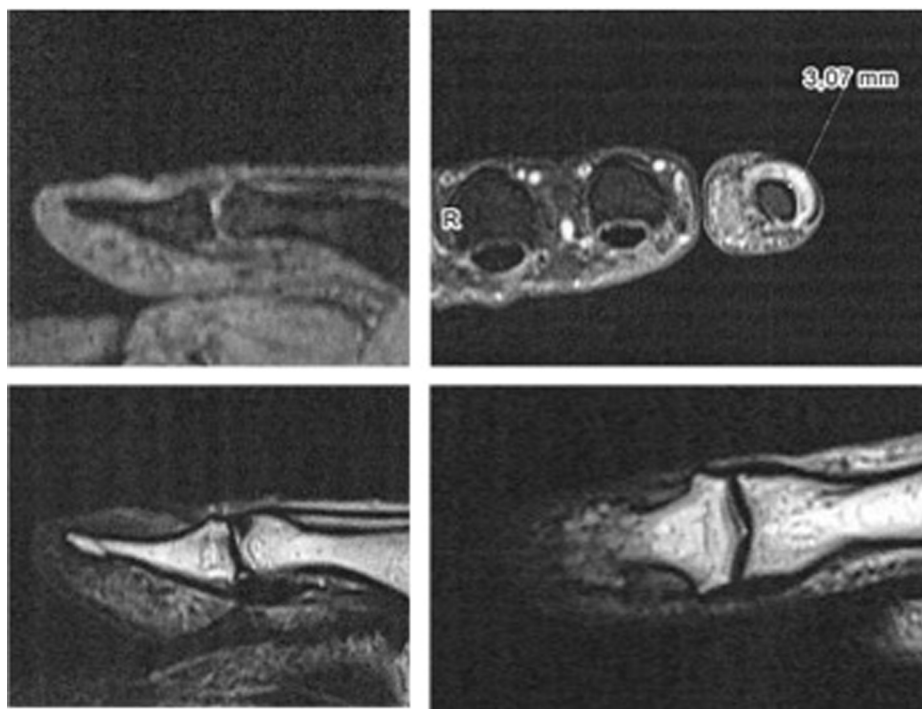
Magnetic resonance imaging (MRI) prior to the operation showing a tumorous broadening of the thumb nail with adjacent tissue reaction but no bone involvement.
